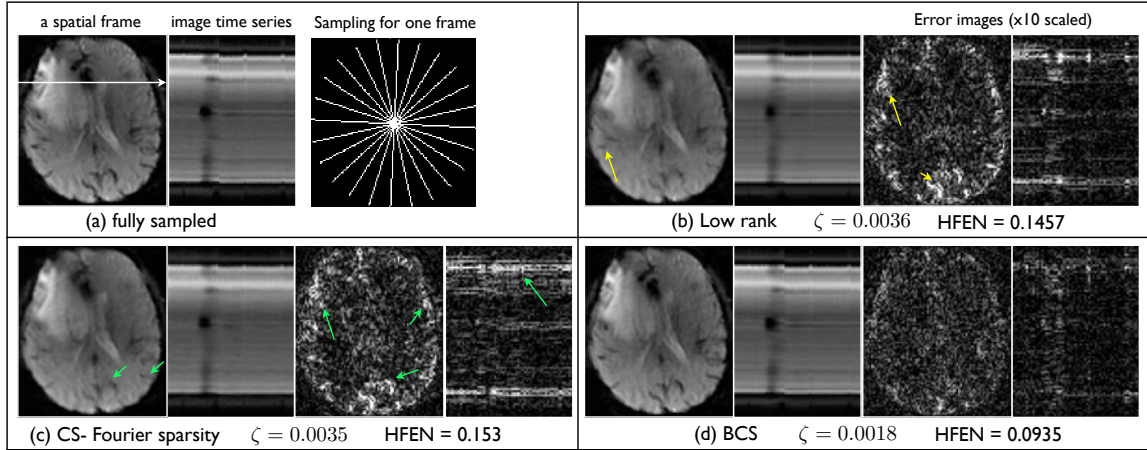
Comparisons of the different reconstructions schemes on a brain perfusion MRI dataset. The fully sampled data in (a) is retrospectively undersampled at a high acceleration of 10.66. The radial sampling mask for one frame is shown in (a), subsequent frames had the mask rotated by random angles. We show a spatial frame, the image time series, and the corresponding error images for all the reconstruction schemes. Note from (b,c), the low rank and CS schemes have artifacts in the form of spatiotemporal blur; the various fine features are blurred (see arrows). In contrast, the BCS scheme had crisper features, and superior spatiotemporal fidelity. The reconstruction error and the HFEN error numbers were also considerably less with the BCS scheme.
